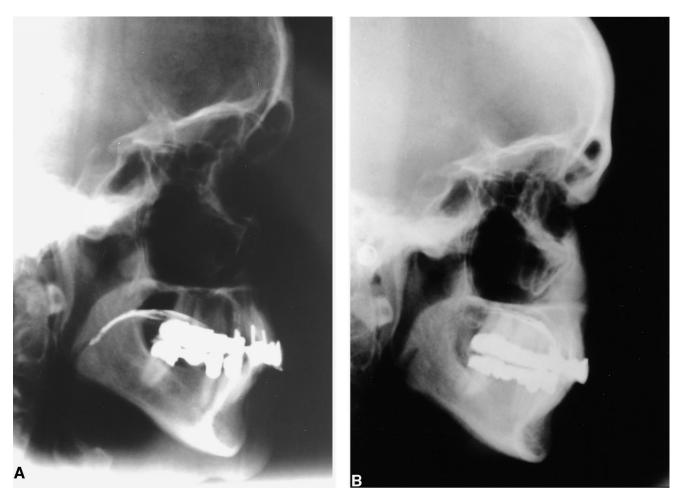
Case 1: Lateral cephalograms. (A) Initial x-ray. (B) Follow-up x-ray after 2.8 years of MAA-treatment.
